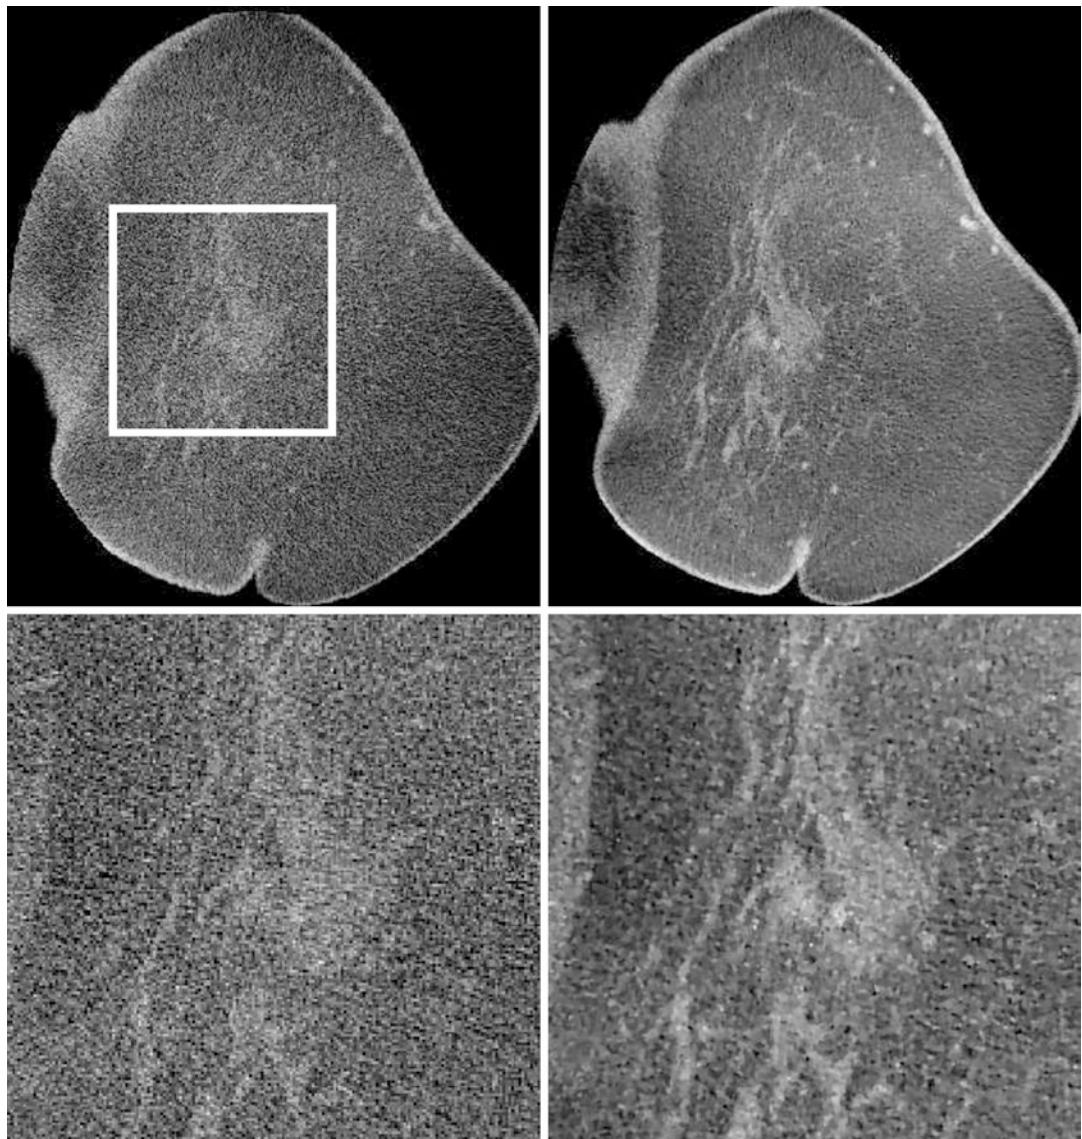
Clinical FDK (left) and ASD-POCS (right) reconstructions for a large-size breast. Data were acquired by use of a dedicated breast CT scanner at low-radiation exposure with 500 projection views over 2π angular
